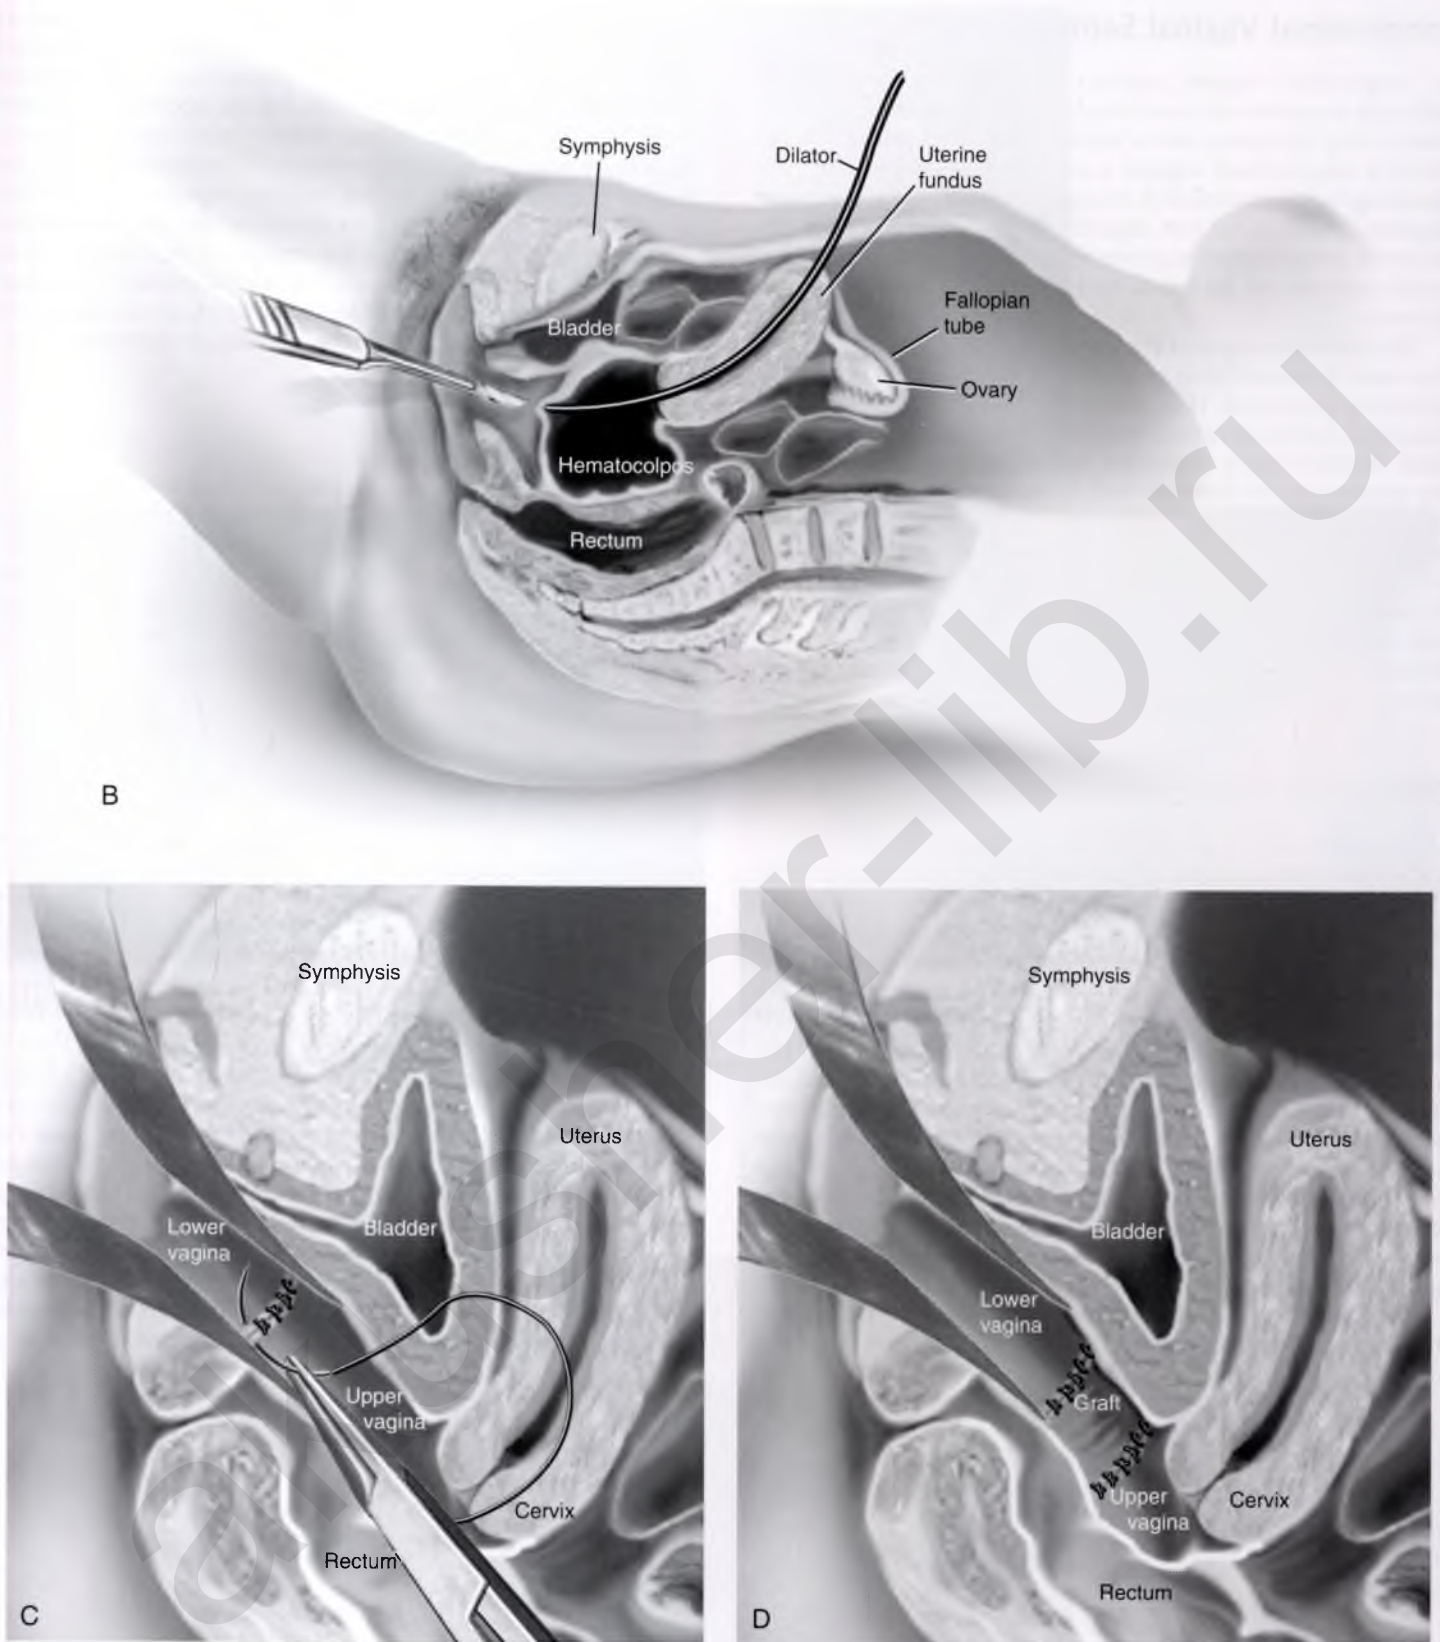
cont'd B. Laparotomy is necessary when the upper vagina cannot be identified after surgical exploration or with the use of abdominal ultrasound. After the abdomen has been opened, a long cervical dilator or uterine sound is passed through the fundus into the uterine cavity and cervix. Pressure is placed against the upper vagina. The rigid dilator is identified vaginally. The upper vaginal mucosa is sharply entered. C. The upper and lower vaginal mucosal edges are approximated with interrupted 3-0 nonreactive, delayed absorbable sutures. D. A split-thickness skin graft may be used when the upper and lower vaginal edges cannot be approximated. An appropriately sized graft is harvested from the buttock and sutured into place. A foam pad covered with a sterile condom can be placed into the vagina, as described for a McIndoe vaginoplasty, to provide maximal contact of the graft with the paravaginal connective tissue.
